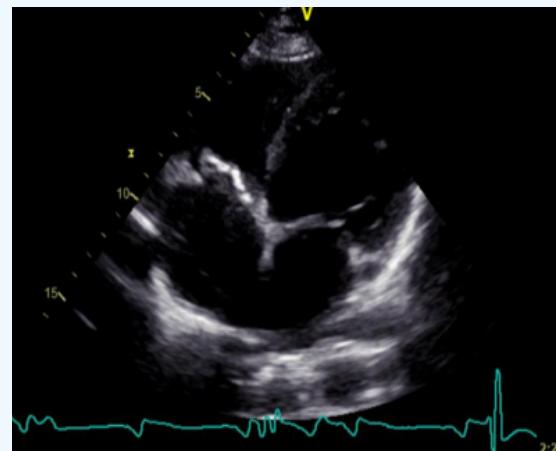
2D echocardiography in the apical 4 chambers view showing thickened leaflets of the bioprosthetic tricuspid valve.
